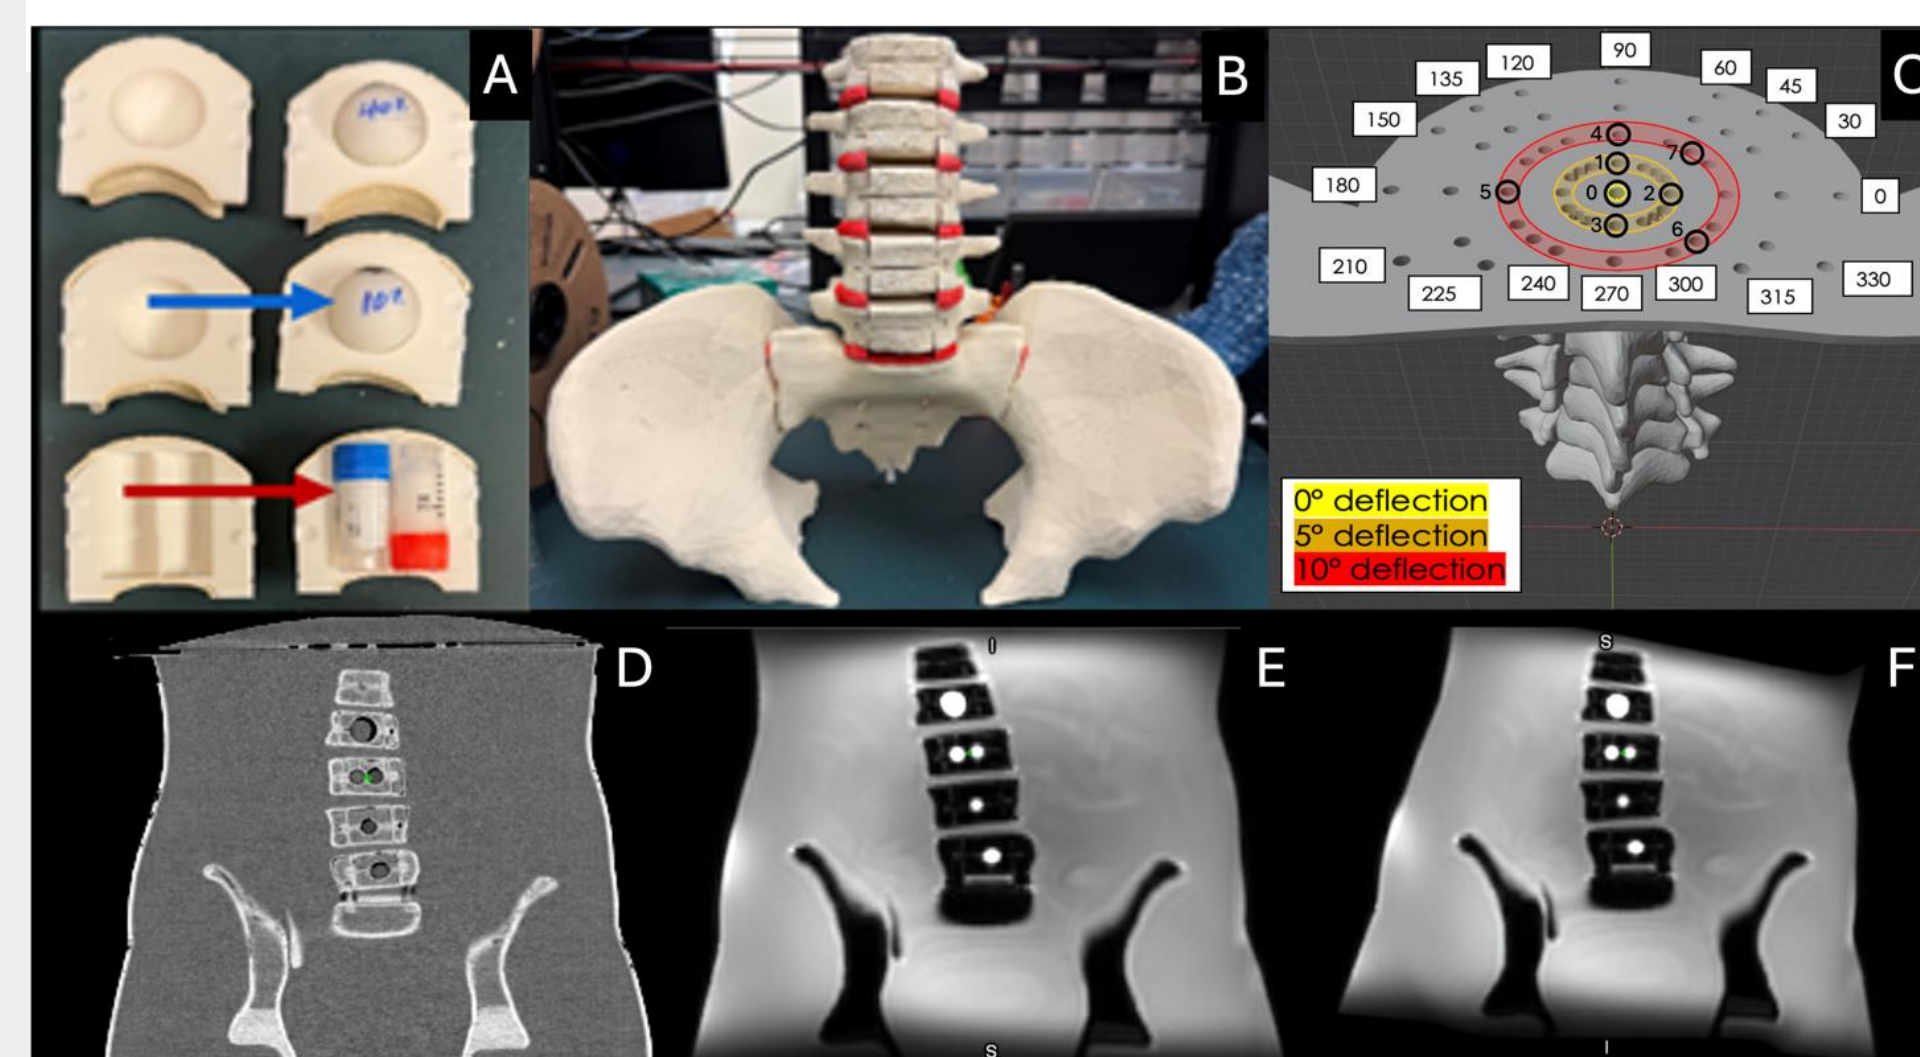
(A) Vertebral bodies that include spherical and vial-based FF inserts. (B) Pelvis and vertebrae region. (C) Available deformed positions with black circles indicating deformed positions (0–7) used. Orange circle has a radius of 7.4 mm and red circle has radius of 14.9 mm from position 0. (D) CT0. (E) MRI acquired with 10° deflection towards patient right. (F) resulting deformed MR image in CT space.
